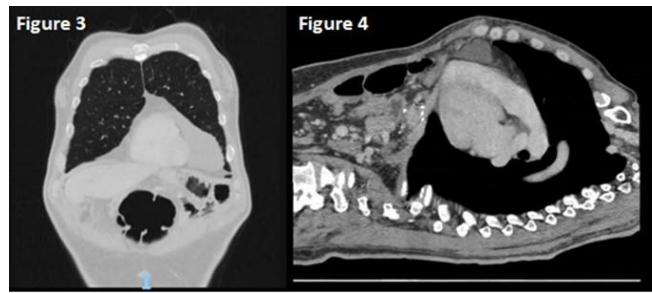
A computed tomography (CT) showed a much smaller pocket with seroma ventral to the mediastinum.
